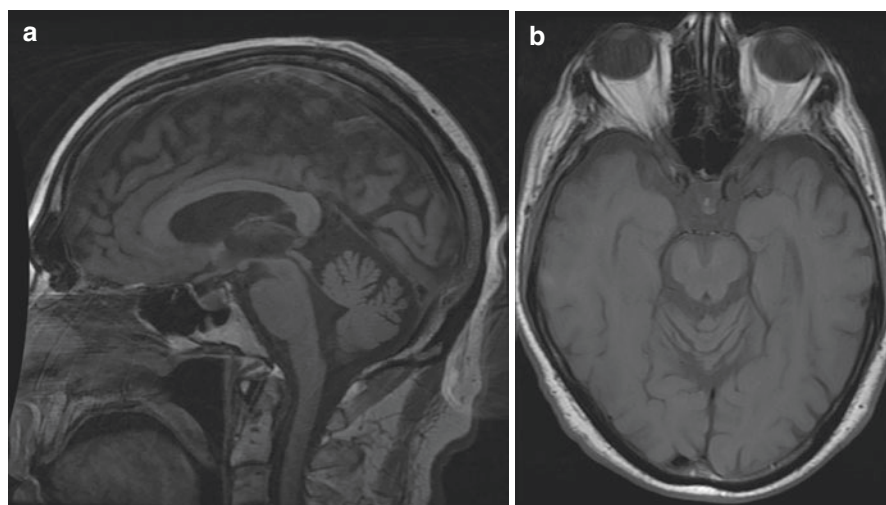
T1 weighted (a) sagittal and (b) axial MRI scan of brain showing atrophy of the mid-brain with normal structure in the pons leading to the “hummingbird” appearance of the brainstem
